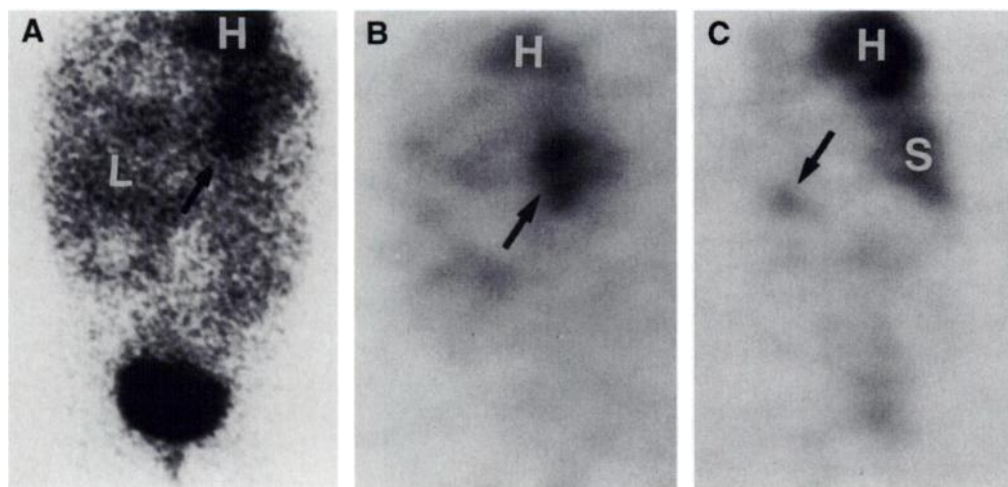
(A) Iodine-123-MIBG scintigram of thorax, abdomen and pelvis (12 min spot view of 200 K counts) 22 hr after injection of 5 mCi showing tracer uptake in a pancreaticoblastoma (arrow) in a 6-yr-old boy. L = liver uptake; H = heart uptake; B = bladder. SPECT images (360° acquisition over 30 min) in the same patient with pancreaticoblastoma (arrow) (B) coronal section, (C) sagittal section. H = heart uptake; S = spleen; tumor = arrow.
